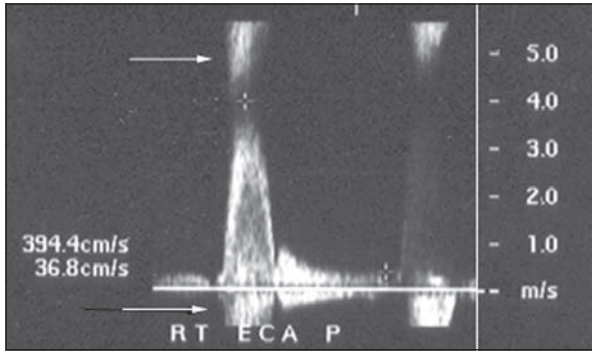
An example of aliasing (arrows). Pulsed wave Doppler ultrasound is limited to a maximum frequency that can be successfully measured with the instrument.
